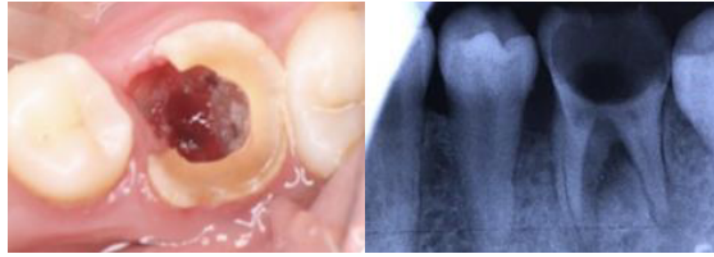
Intraoral and Radiograph before treatment.
